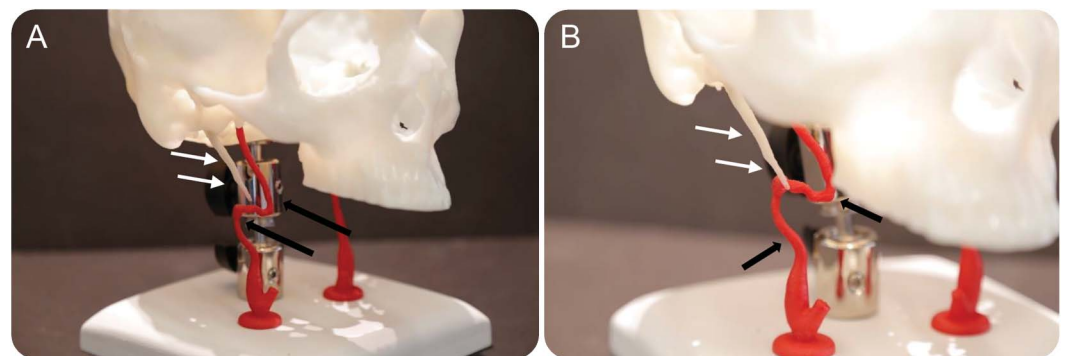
CT angiography of styloid-carotid artery syndrome
